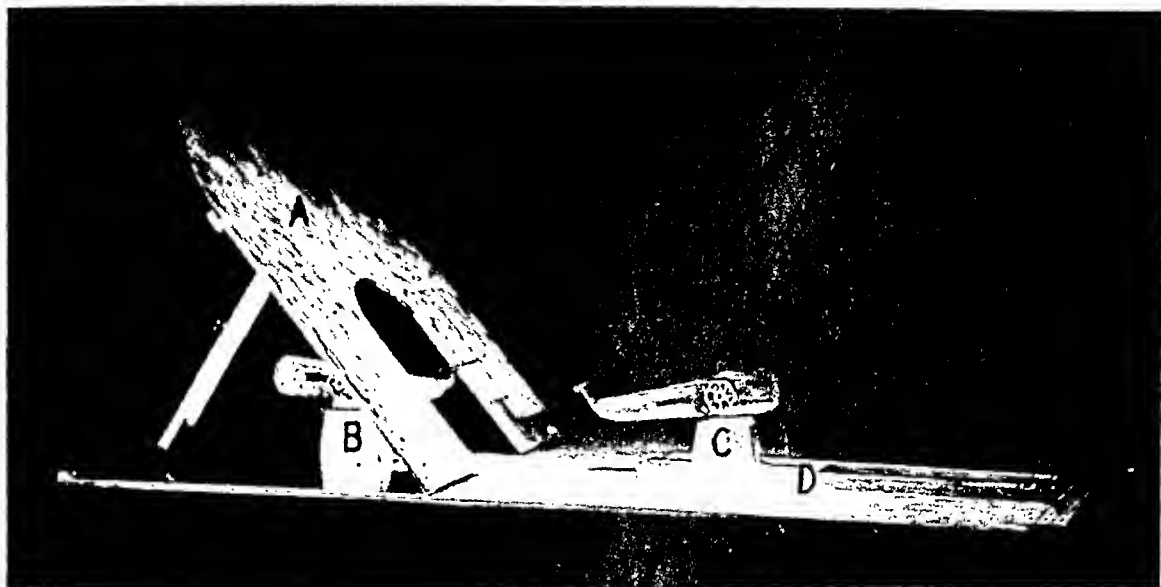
Sectional photograph of roentgen pelvimeter. *A*, backrest with device to alter the angle; *B*, posterior post fixed to platform; *C*, anterior post mounted on a sliding plane, *D*, so that after adjusting the movable arm the post can be temporarily moved away so that the patient may get off the table. After she has been roentgenographed the post is shifted back into place and the two cross-arms then mark in space the plane of the superior strait. The perforated plate is laid over them and the second exposure made.
